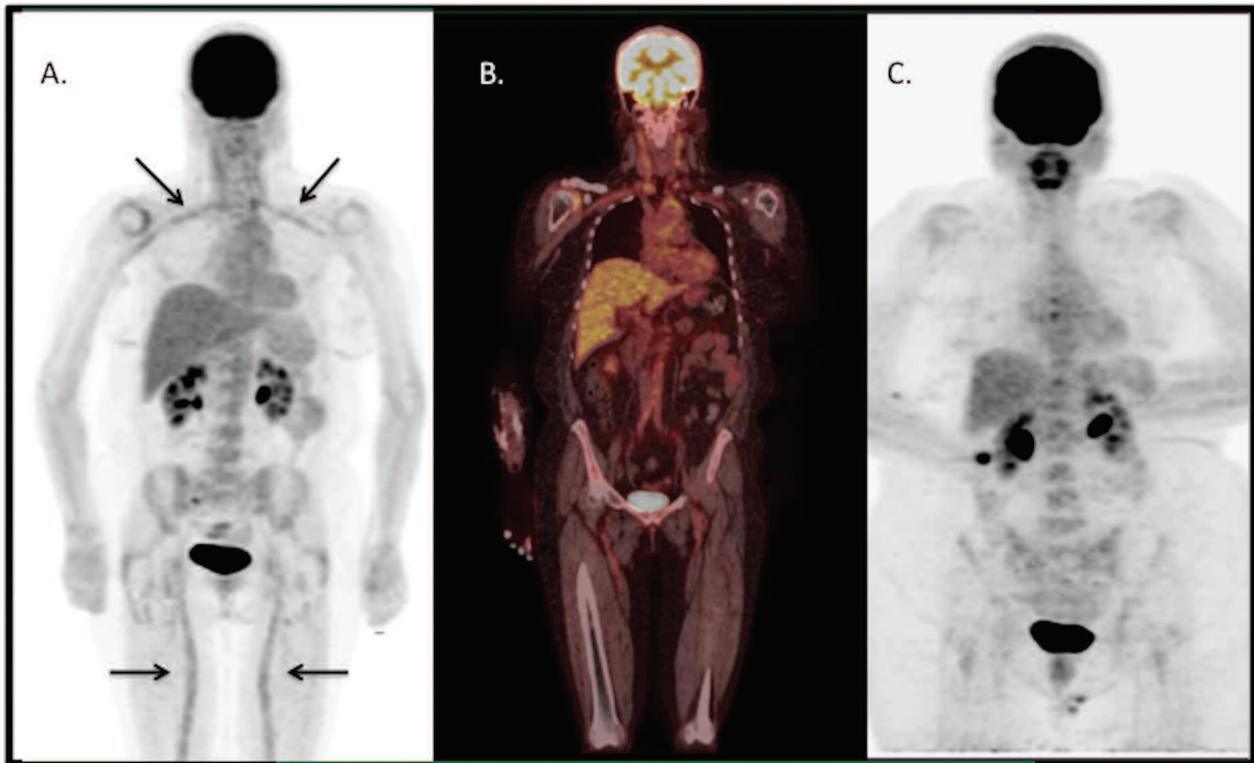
Acquired PET/CT images in patients with GCA and controls. A. A 3-D MIP PET image. Black arrows indicate areas of increased vascular FDG uptake. B. Coronal fused PET/CT image from a GCA patient with a vascular uptake score of 16.5/24. C. A 3-D MIP PET image from a control subject with a vascular uptake score of 2.5/24. PET/CT: positron emission tomography/computerized tomography; GCA: giant cell arteritis; MIP: maximum intensity projection; FDG: 18F-fluorodeoxyglucose.
